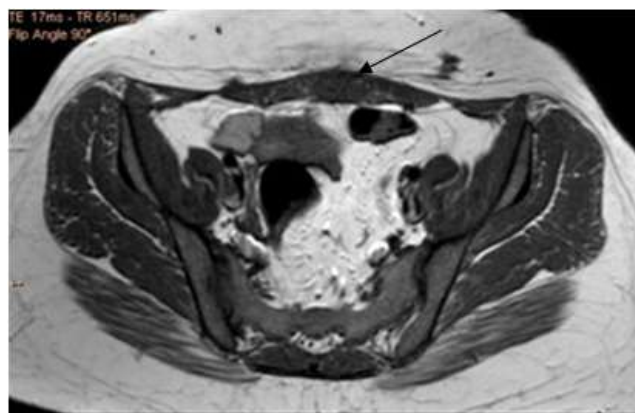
MRI picture, arrow points to abdominal wall lesions.
